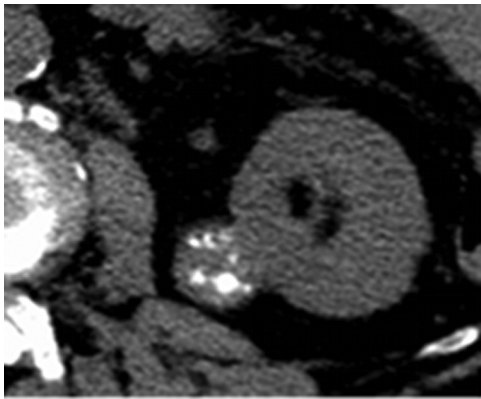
Papillary carcinoma with multiple rounded calcifications. Unenhanced CT.
